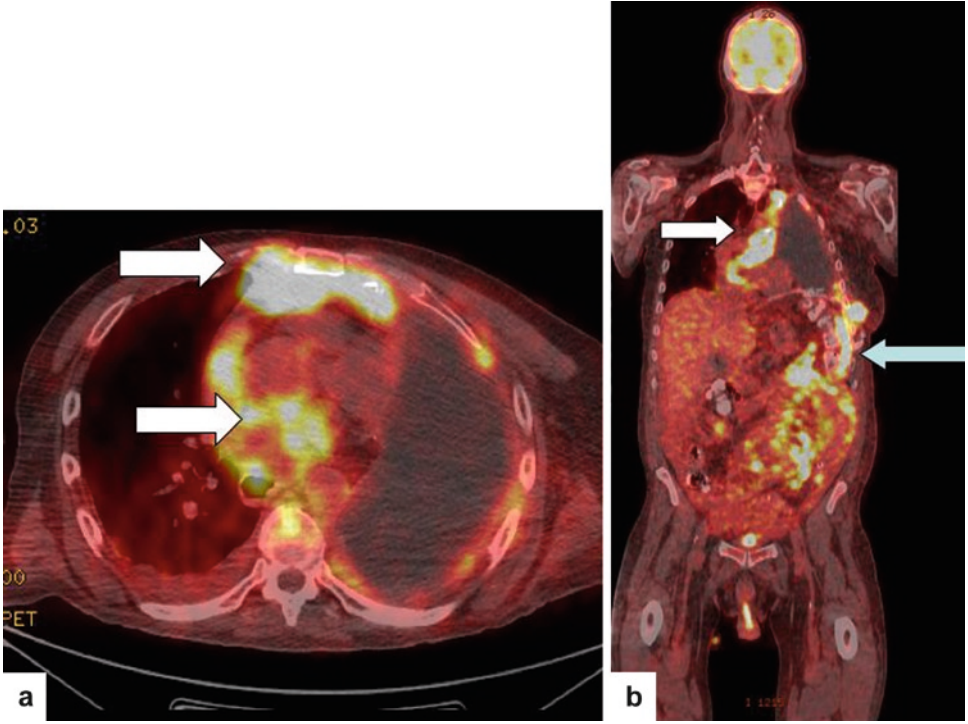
(a) and (b) axial and Coronal ¹⁸F-FDG fused images showing recurrent disease involving the mediastinum, left lateral chest wall and intra-abdominal disease post left extrapleural pneumonectomy (*white arrows*)
